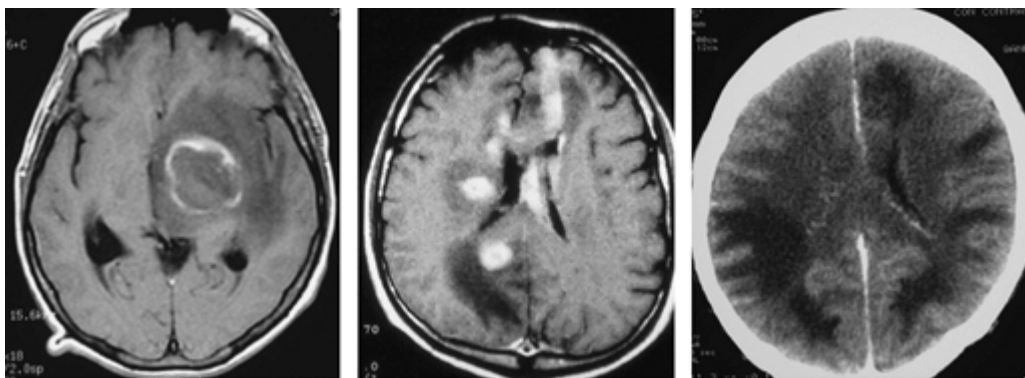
Neuroimaging findings in AIDS patients with seizures. Gadolinium-enhanced, T1-weighted MRI showing toxoplasma brain abscess (*left*) and intracranial lymphoma (*center*), and contrast-enhanced CT showing progressive multifocal leukoencephalopathy (*right*).
